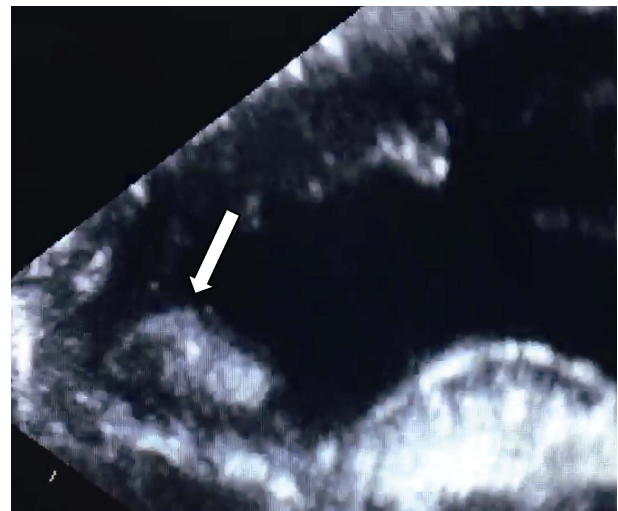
Still image of transthoracic echocardiogram depicting the papillary fibroelastoma (arrow) attached to the septal wall of the left ventricle.
